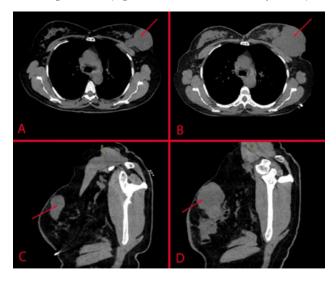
Mass of the mammary gland with a difference of one year (CT scan of the chest,). A - CT image from 2021 (axial section, the mass is indicated by an arrow); C - CT image from 2022 (axial section, the mass is indicated by an arrow); C - CT image from 2021 (sagittal section, the mass is indicated by an arrow); D - CT image from 2022 (sagittal section, the mass is indicated by an arrow).
